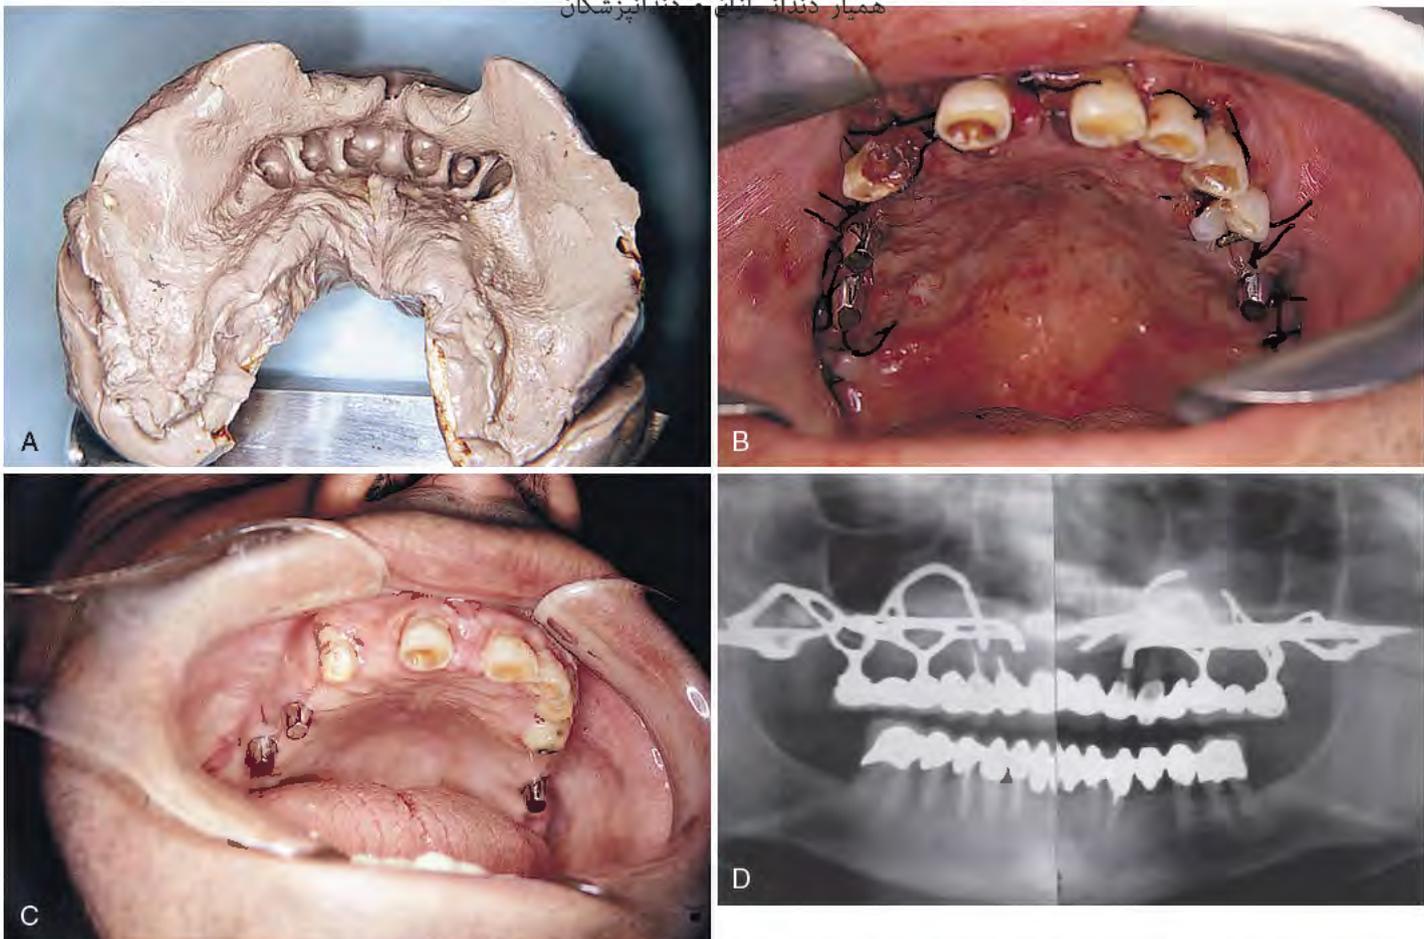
A, The universal implant is made with an impression that must include the natural dentition. B, Placement of a universal casting should include abutments made parallel to the patient's natural teeth. The integrity of the high palatal vault is maintained by using an EZ Tray stent. C, After healing, the implant abutments are seen to emerge from zones of fixed gingivae. After 6 to 8 weeks, prosthodontic reconstruction can be undertaken. D, A radiograph of a fully restored maxillary universal pterygohamular subperiosteal implant shows good peripheral extension and a functional relationship between natural and implant abutments.
